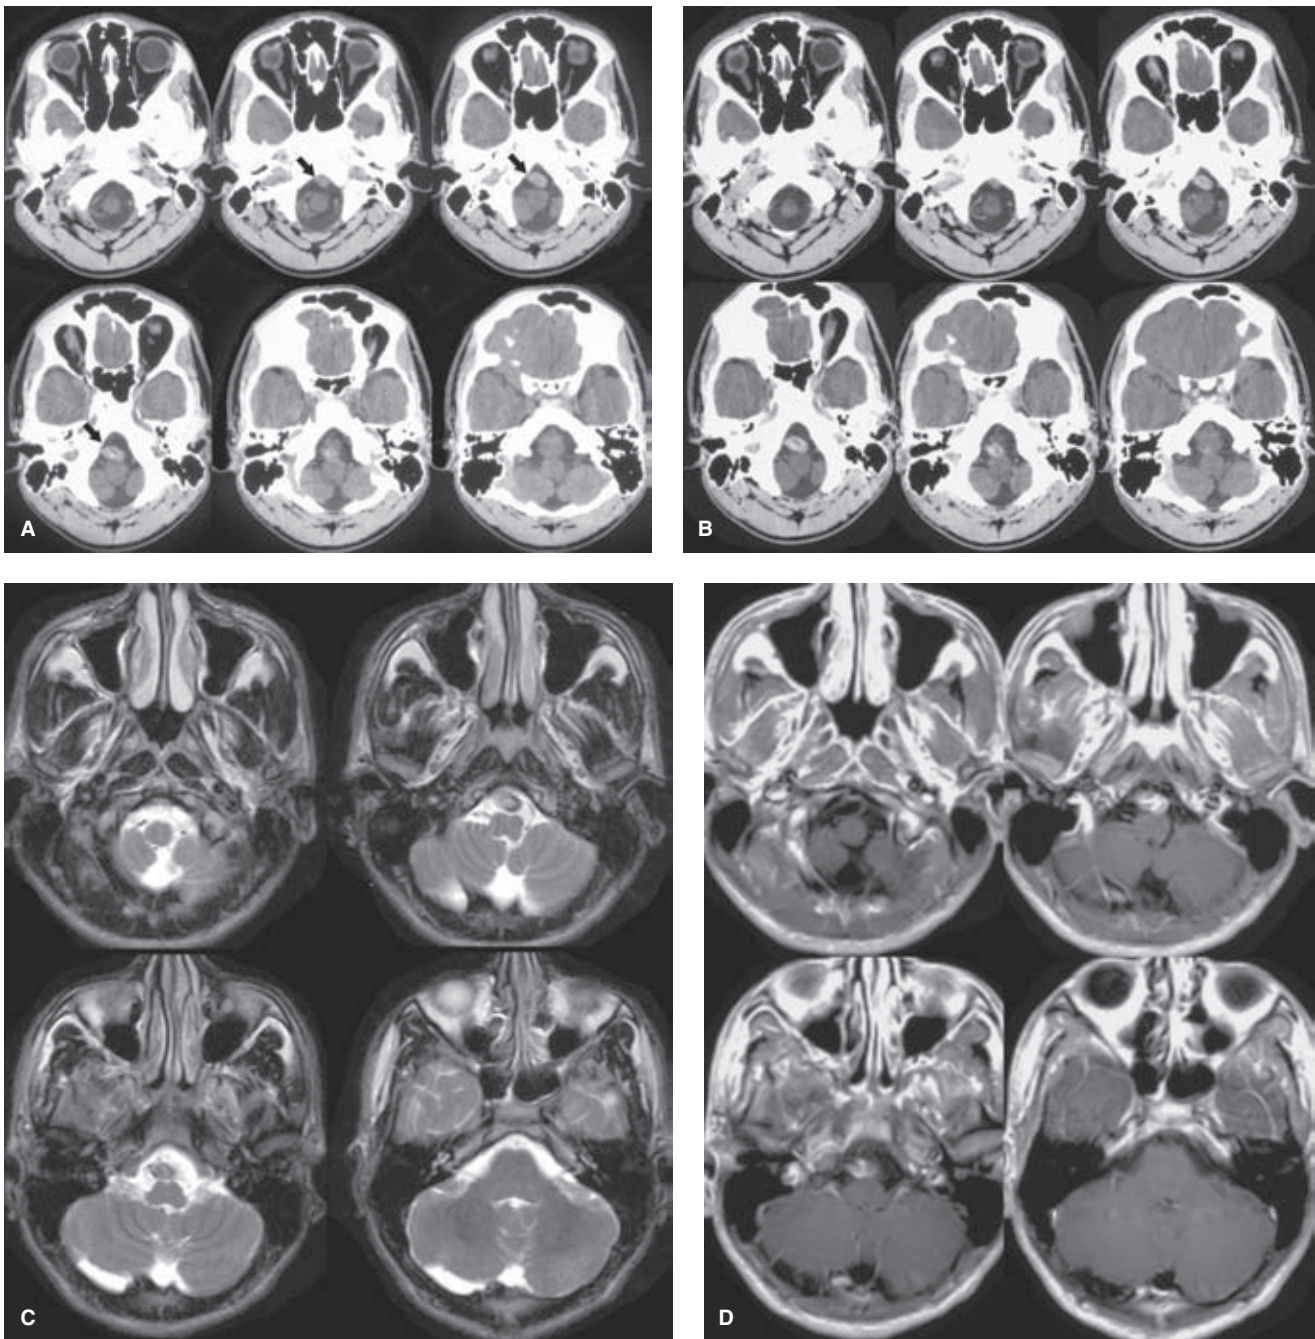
(A–H) Vertebral-basilar dissection in a teenager presenting with mass effect. A teenager presented with a 3-week history of syncopal episodes, headache, and fluctuating degrees of left-sided hemiparesis and sensory disturbance. The likely diagnosis is that of a dissecting aneurysm of the vertebral-basilar junction. The high-density appearance on the noncontrast CT examination (A) is suggestive of intramural or laminar thrombus, confirmed on the contrast-enhanced CT (B) and MRI (C and D) images with evidence that enhancing lumen is only a small component of the mass formed. The principal concern for this lesion in the acute phase is progression to rupture or extension of the dissection higher in the basilar artery with probable injury to the brainstem. Rupture with subarachnoid hemorrhage from an aneurysm in this location would carry a substantial morbidity and mortality in any circumstance, but the likelihood of further hemorrhage from a dissecting aneurysm is probably higher than that of a berry aneurysm. Surgical or endovascular treatment for a ruptured dissecting aneurysm is probably more hazardous than for a berry aneurysm due to the possibility of disintegration of the aneurysm from any type of manipulation. The fragility of a dissecting aneurysm in this location would probably demand that even angiographic images should be obtained gingerly with gentle hand injections of contrast. (*continued*)
